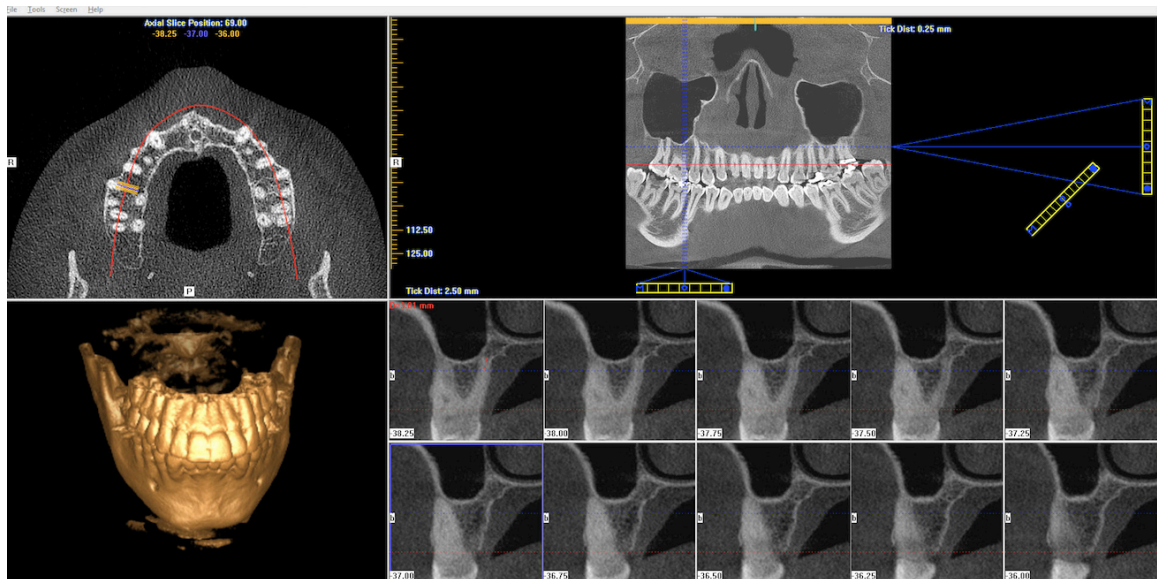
Implant screen of CBCT
